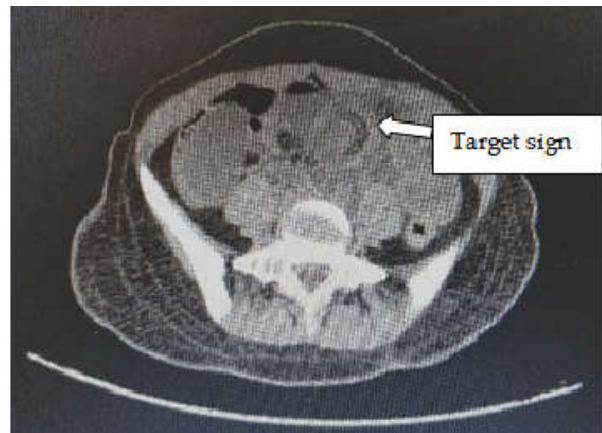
CT Abdomen s/o Target Sign
